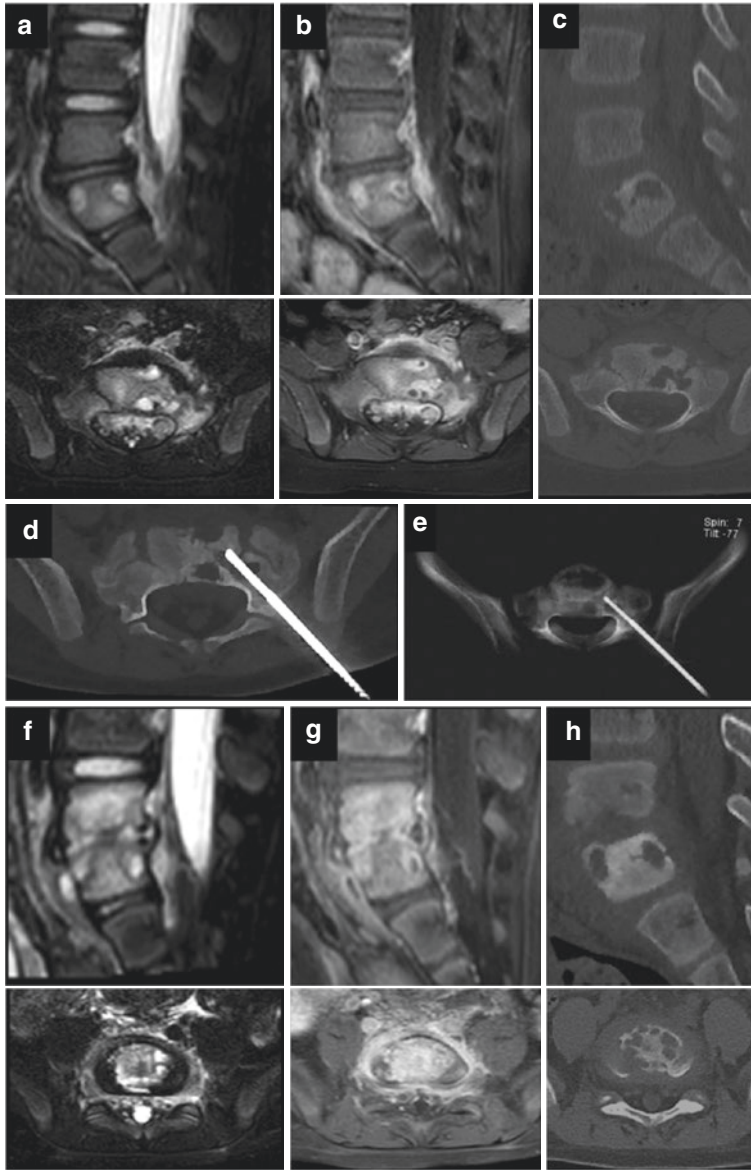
Two year old baby girl, presenting with back pain and refusing to walk. T2-weighted fat suppressed (a), GD-enhanced fat suppressed T1-weighted (b) and CT scan (c) on sagittal plane and on axial plane at S1 level. Images show edema and diffuse contrast enhancing of marrow in S1 vertebra, with coexistent areas of irregular and confluent osteolysis, such as a focus of osteomyelitis; adjacent prevertebral and epidural phlegmon is also appreciable. Axial CT scan (d) and MIP Volume Reconstruction (e). Percutaneous bone biopsy via left trans-pedicle access reveals inflammatory infiltrate in the osteolytic lesion. T2-weighted fat suppressed (f), GD-enhanced fat suppressed T1-weighted (g) and CT scan (h) in the sagittal plane and in the axial plane passing through the space L5-S1. Images show the evolution in spondylodiscitis of the discosomatic unit L5-S1. Altered signal and enhancement are more extensive, involving the adjacent narrowed intervertebral disc, with irregular definition of the adjacent L5 endplate due to the cortical osteolysis. Prevertebral and epidural phlegmon are also still evident
